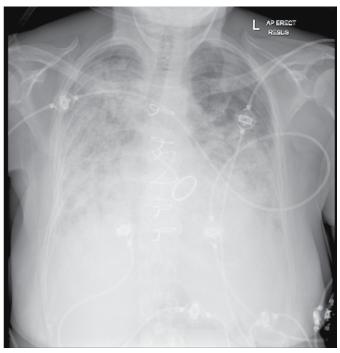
Chest X-ray on presentation with bilateral interstitial infiltrates.
